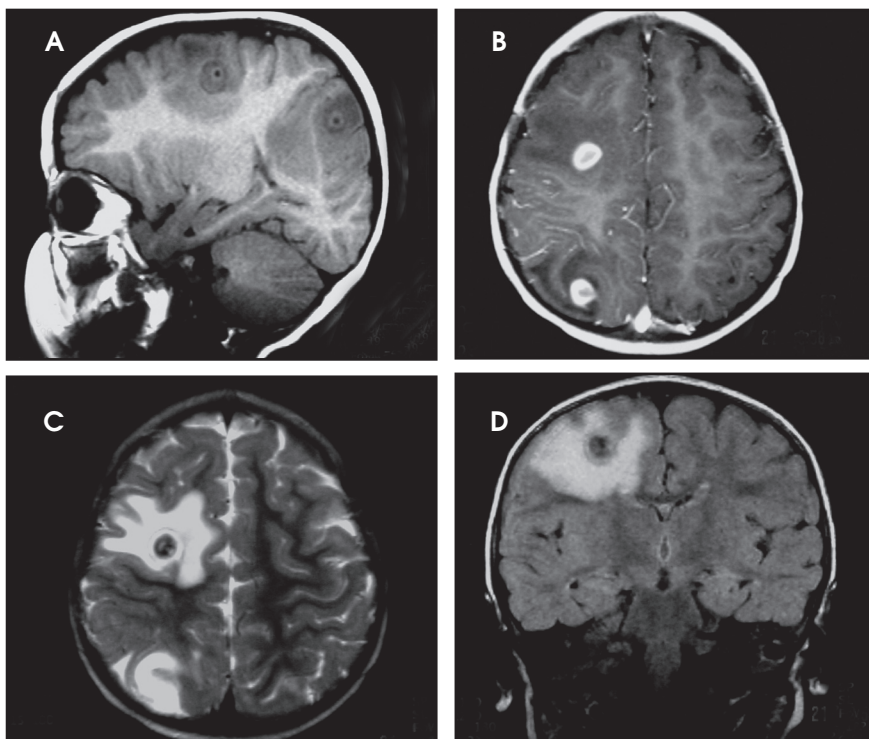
(A) A sagittal T1W image shows the child's brain without gadolinium. (B) An axial T1W image after IV gadolinium administration, (C) an axial T2W image, and (D) a coronal FLAIR image is depicted.
